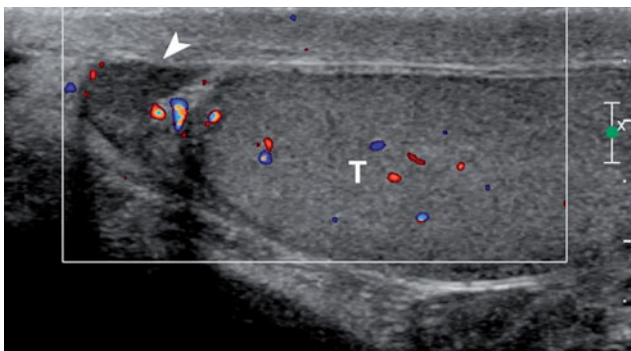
Normal anatomy. Sagittal scan of a normal testis (*T*). The head of the epididymis (*arrowhead*) can be seen at the upper pole. Color Doppler demonstrates the presence of vessels within both the testis and the epididymis
